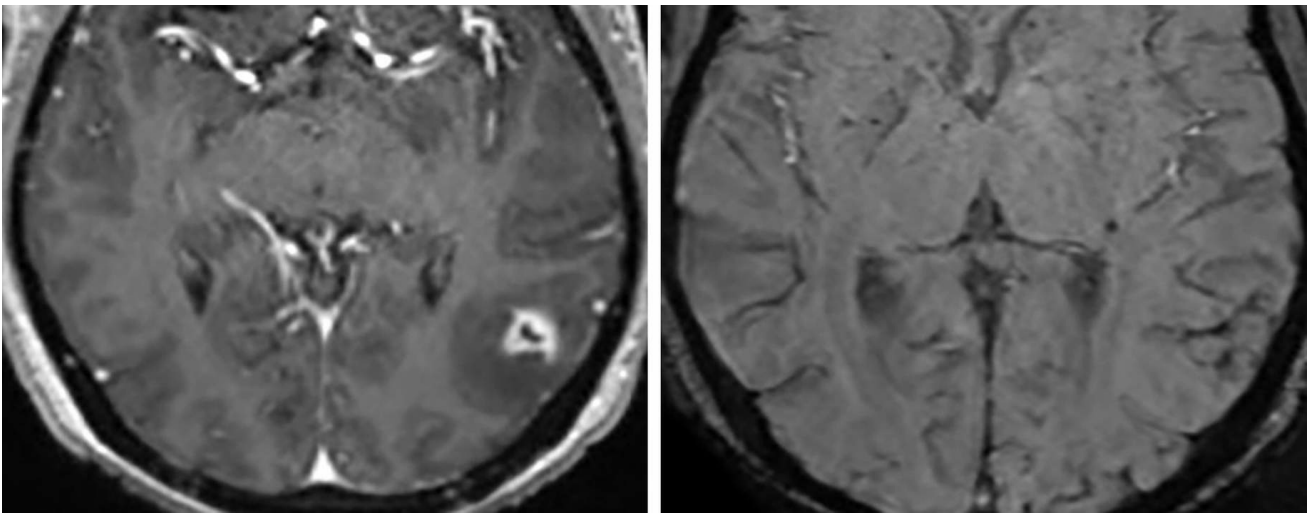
Patient with HIV with a low CD4 count who was not taking highly active antiretroviral therapy (HAART) around the time of imaging. These images demonstrate at least 2 T1-hypointense (top left), FLAIR-hyperintense (top right) lesions centered within the left parietal cortex and left basal ganglia. (Middle) Both lesions demonstrate punctate, central restricted diffusion. The lesion in the left parietal cortex has a rim of thick enhancement (bottom left), and there is minimal associated susceptibility artifact (bottom right), likely reflecting microhemorrhage.
